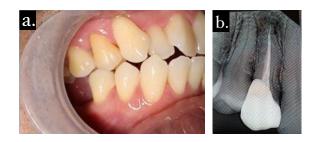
Post-operative image and post-operative radiograph image.
